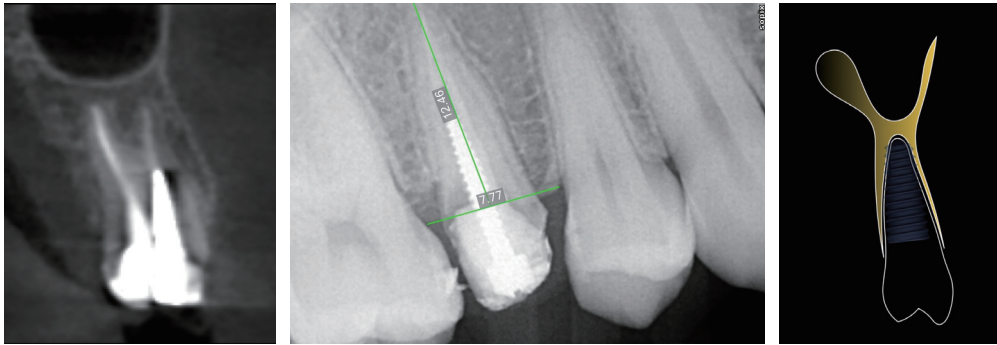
Periapical X-ray showing sufficient mesial-distal bone
